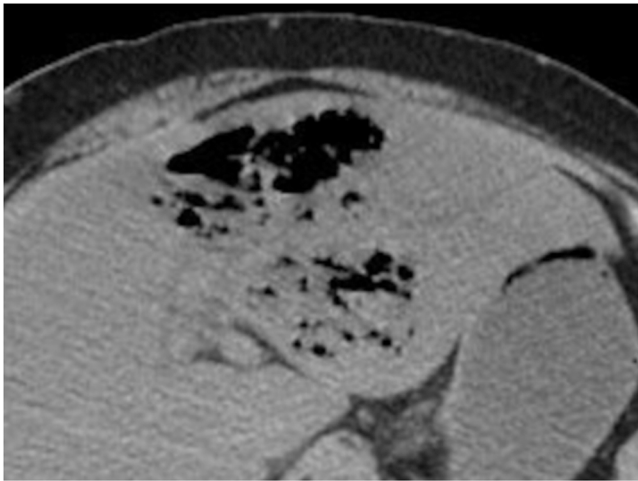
Abdominal computed tomography showing a gas forming lesion in the left hepatic lobe, a finding consistent with emphysematous liver abscess.
